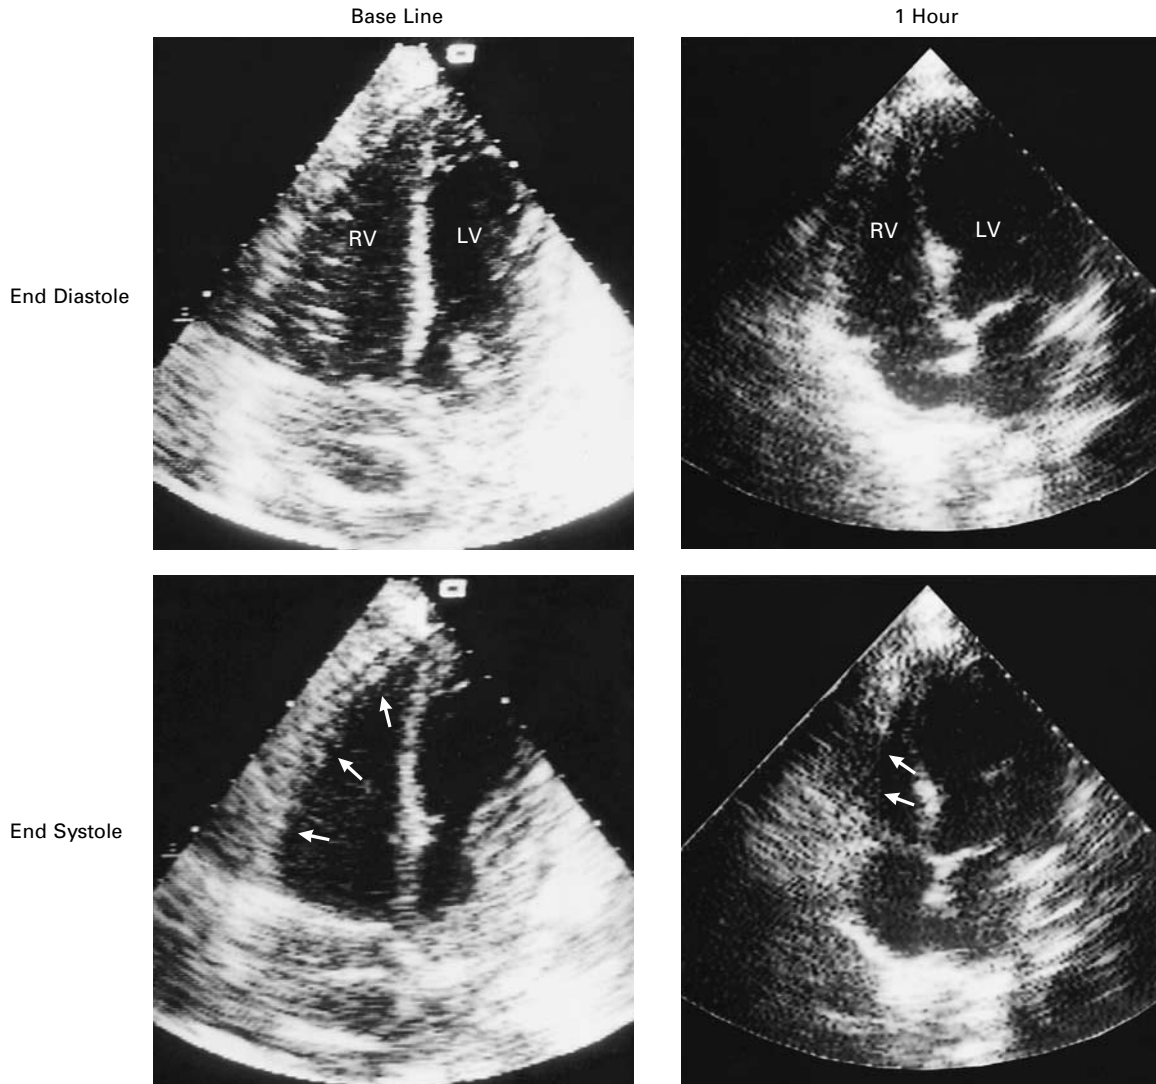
Echocardiographic Images from a Patient with Acute Inferior Myocardial Infarction and Right Ventricular Ischemia in Whom Angioplasty Was Successful.
